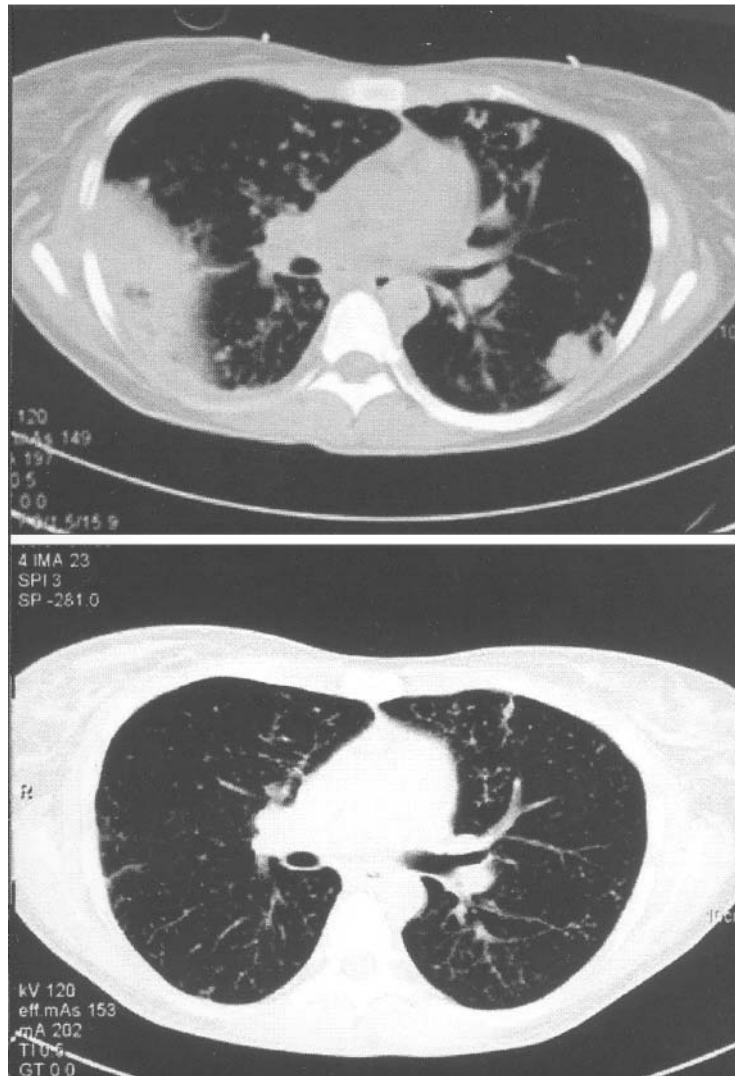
CT scan of the lungs showing the response of the disease a) before treatment and b) after treatment.
